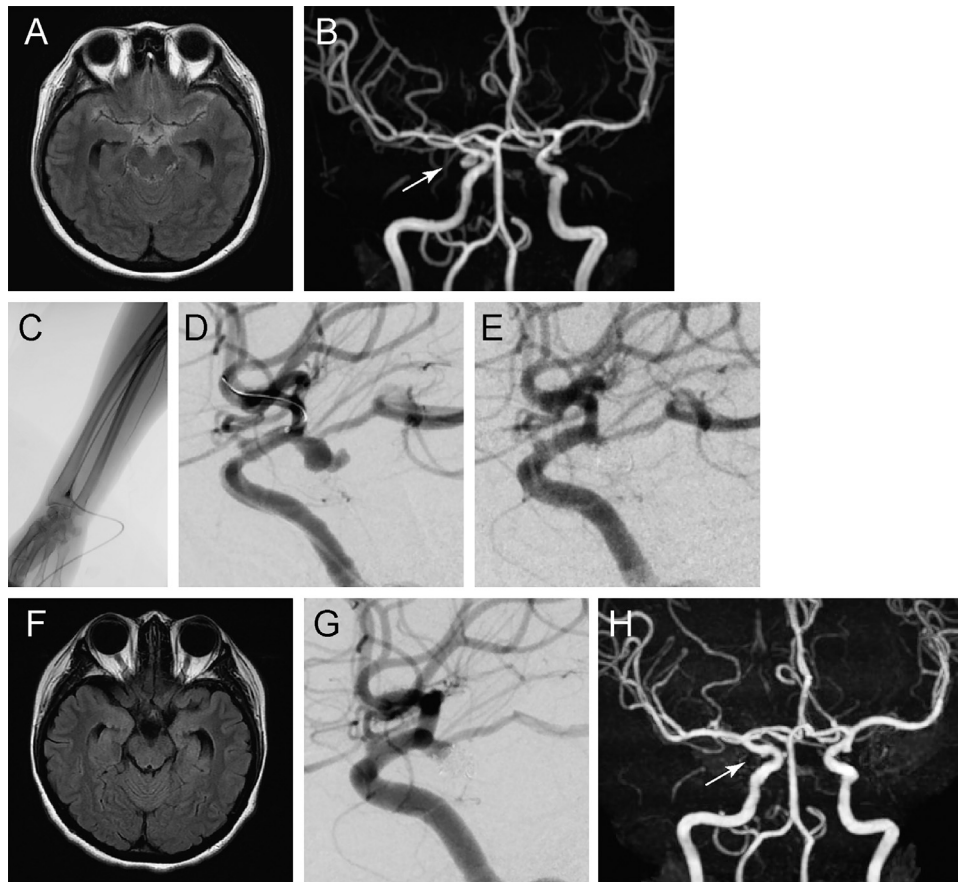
(A) Axial fluid-attenuated inversion recovery (FLAIR) magnetic resonance (MR) imaging at initial presentation showing subarachnoid hemorrhage (SAH) in the basal cisterns and bilateral Sylvian fissures. (B) MR angiography at initial presentation revealing the right posterior communicating artery (PcomA) aneurysm (arrow). (C) Intraoperative fluoroscopy showing the sheath inserted from the right radial artery. (D and E) Intraoperative right internal carotid artery (ICA) angiography before (D) and after (E) coil embolization of the right PcomA aneurysm. (F) Axial FLAIR MR image at 1 postoperative month presenting the disappearance of SAH and no hydrocephalus. (G) Right ICA angiography at 6 postoperative months showed a small residual neck of the PcomA aneurysm. (H) MR angiography at 1 postoperative year revealed no progression of the aneurysmal recurrence (arrow).
